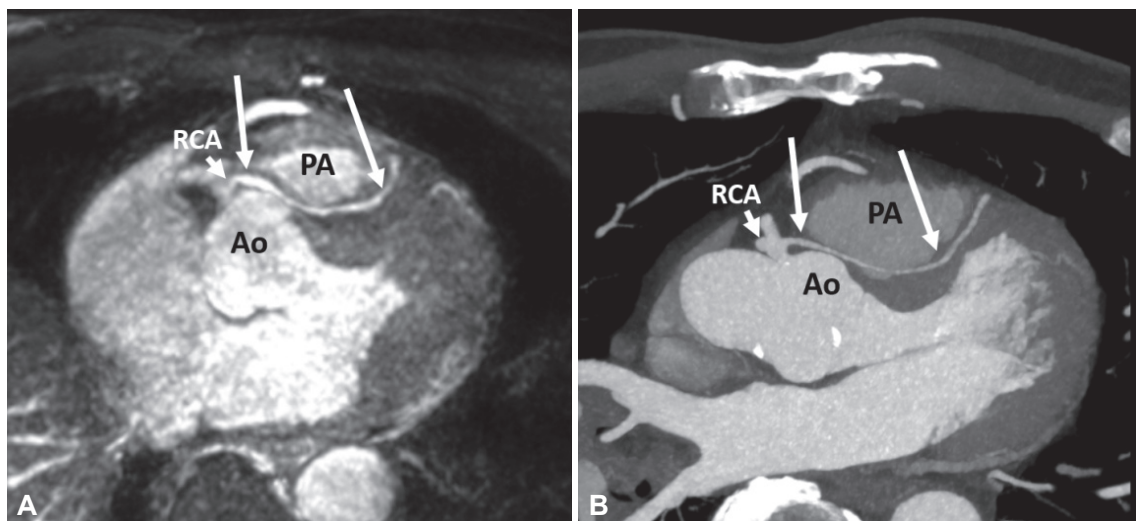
Maximum-intensity projection images of whole-heart coronary MRA acquired with a gradient-echo sequence at 3 T (A) and reformat CT coronary angiography (B) in a young adult showing anomalous left anterior descending artery (arrows) that arises from the proximal segment of the right coronary artery (RCA) and runs in an inter-arterial course between the aorta (Ao) and main pulmonary artery (PA). Sufficient diagnostic data were obtained from the MRA study. MRA: magnetic resonance angiography.
